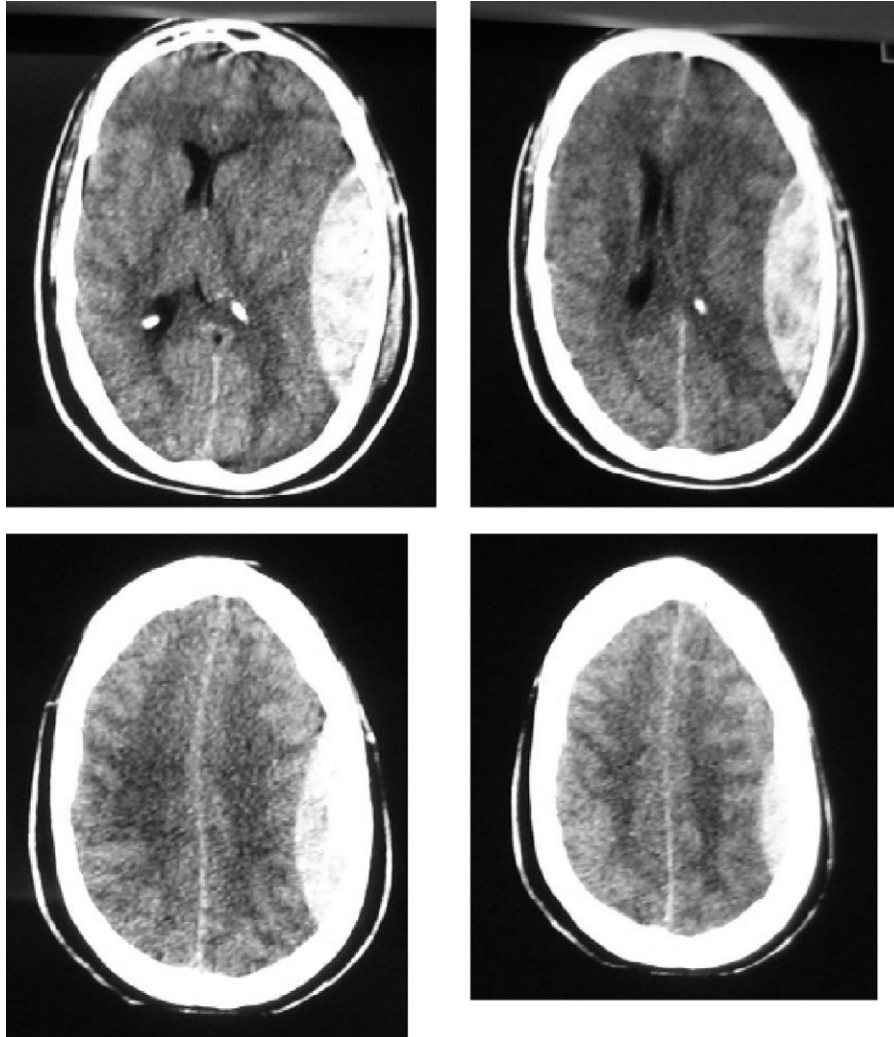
CT scan of the patient in Case 1, with a large left temporal epidural hematoma, with left to right midline shift.
